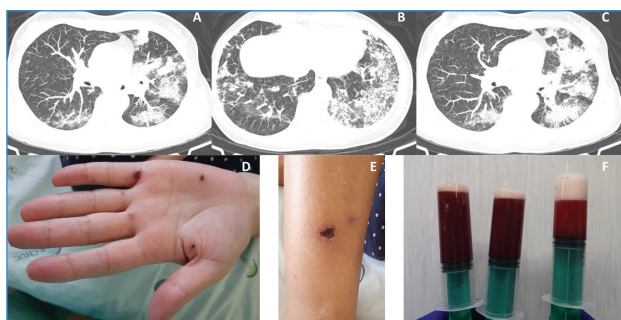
A, B and C: Chest CT scans showing ground glass opacities and heterogeneous parenchymal consolidations; D and E: Purpuric and ulcerated skin lesions in the left hand and in the right leg. F: Bronchoalveolar lavage revealing a progressively (right to left) hemorrhagic fluid.
